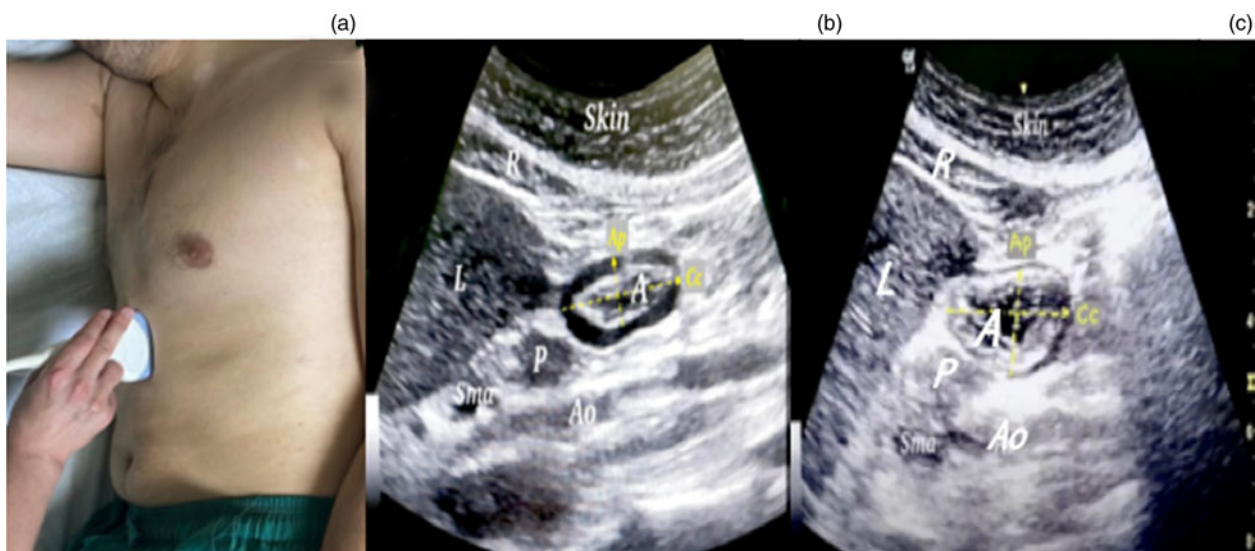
(a) Gastric ultrasound scanning of a patient in the right lateral decubitus position using a curved array low-frequency probe. (b) Gastric ultrasound scan of a patient before anaesthesia induction. (c) Gastric ultrasound scan of a patient before removal of the pharyngeal packing, following completion of surgery. R = rectus abdominis; Ap = anteroposterior; L = liver; A = antrum; Cc = cranio-caudal; P = pancreas; Sma = superior mesenteric artery; Ao = aorta
